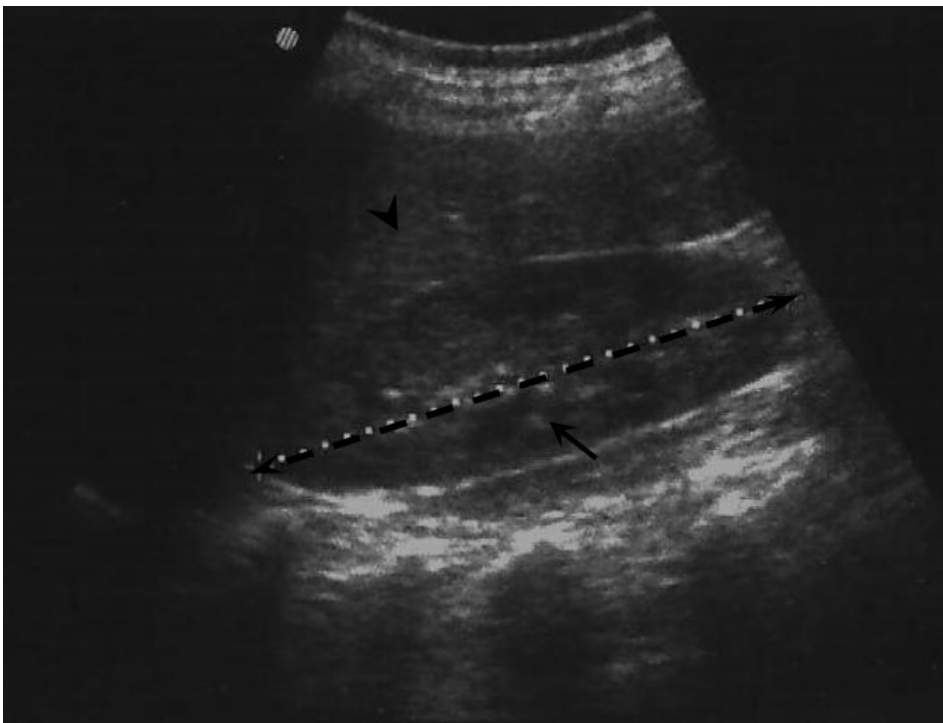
Sonogram showing the assessment of renal size using the longitudinal dimension. Black arrow head point to liver, while black arrow point to right kidney.
